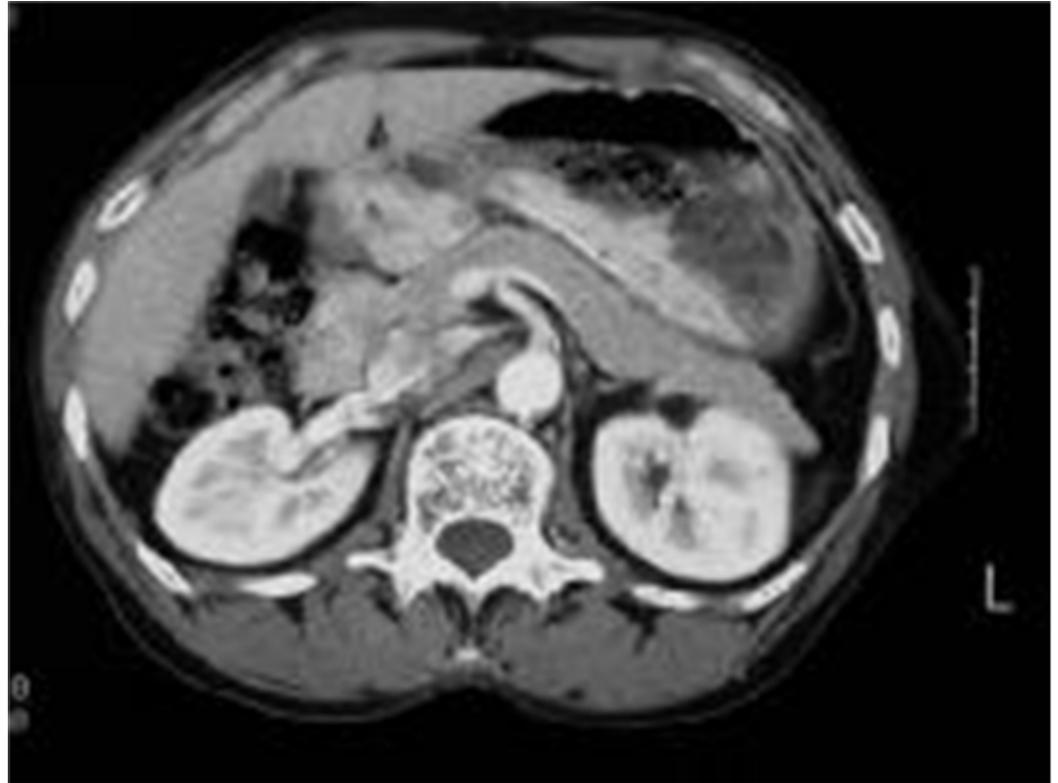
CT of pancreas divisum. Sequential axial CT images demonstrate separate pancreatic ducts of Santorini and Wirsung to the region of the minor and major ampulla, respectively
